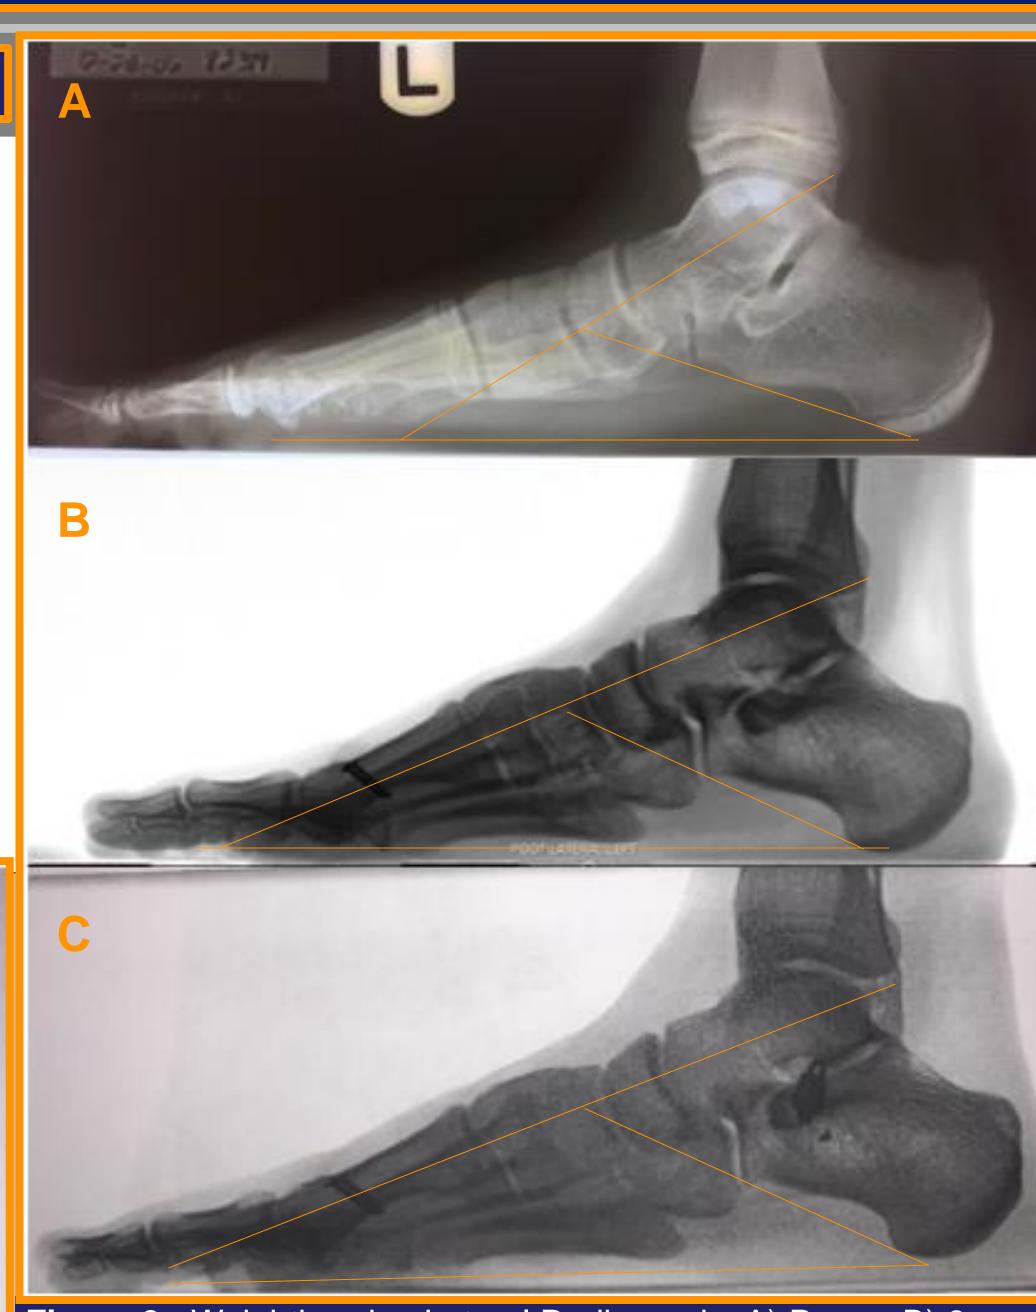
Weightbearing Lateral Radiographs A) Pre-op B) 8 year Postop C) 11 year Post-op.
